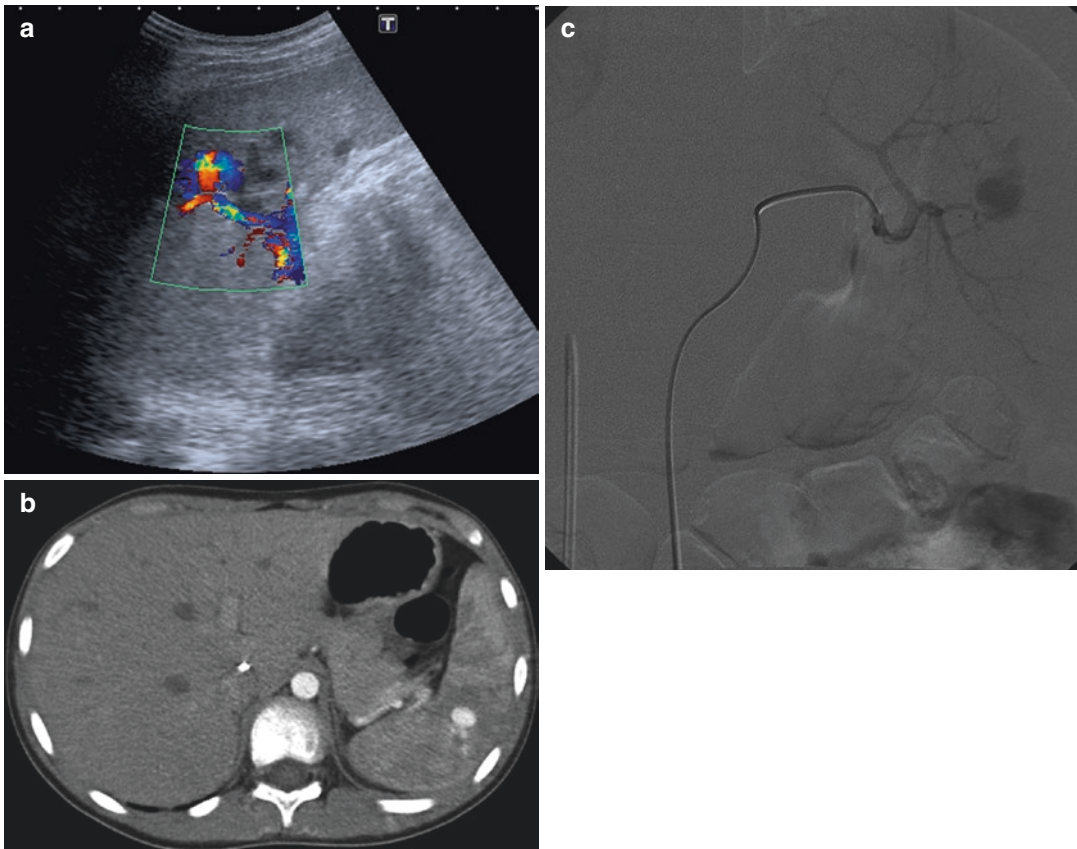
Ten year old boy. Splenic trauma. (a) Control US with Doppler shows pseudo aneurism at day 10. (b) CT with contrast (arterial phase) confirmed the vascular
